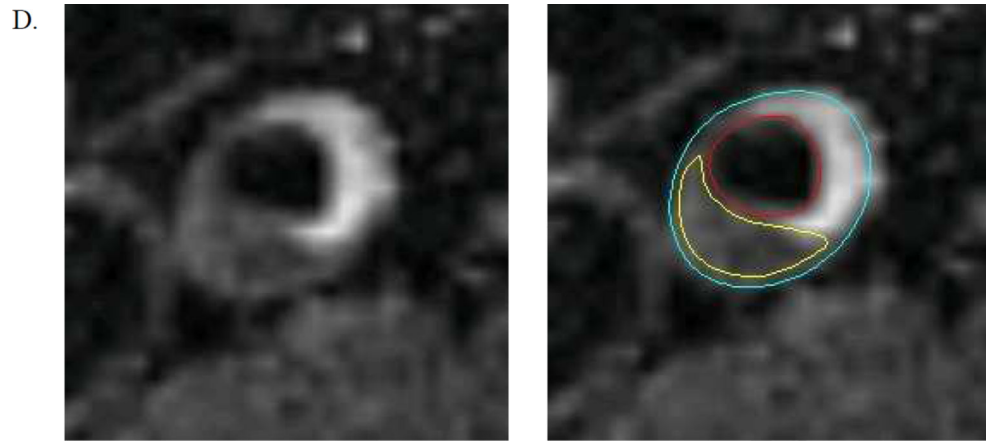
MRI images of the proximal superficial femoral artery (SFA) from a participant in the Walking and Leg Circulation Study III cohort
